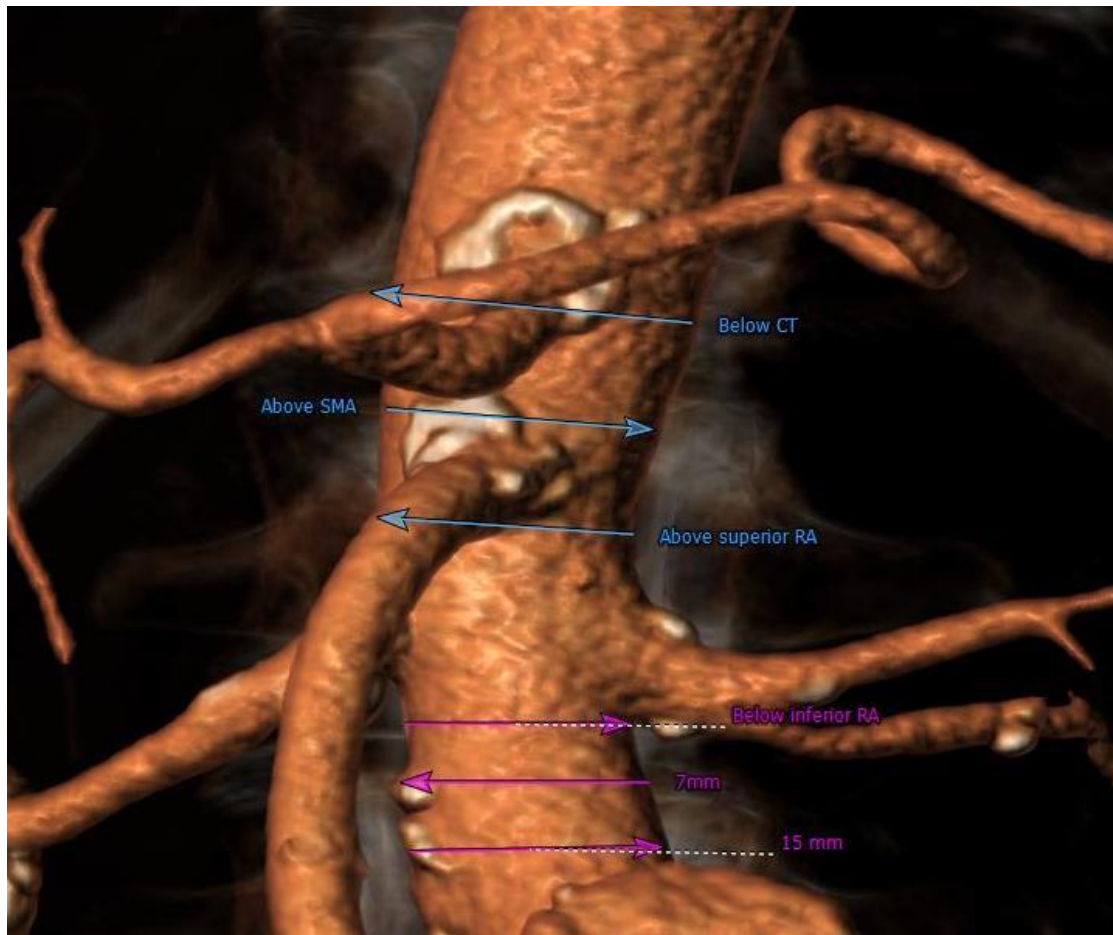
Three infra-renal and three supra-renal aortic diameters were estimated at the pre-operative and 1st year computed tomography angiography. Infra-renal diameters were calculated at just below the lowest main renal artery, 7mm and 15mm while the supra-renal diameters were estimated just above the superior renal artery, the superior mesenteric artery and just below the celiac trunk. These landmarks were used to permit repetition of the measurements at the CTA of the 1st year. SMA: superior mesenteric artery.
